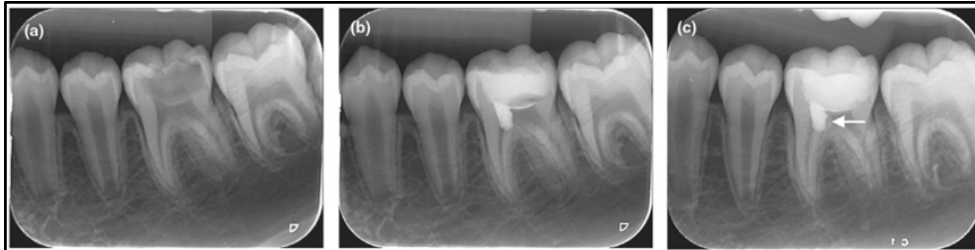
Left mandibular first molar (#36) had caries close to the pulp with a poor occlusal filling, in a 11-year-old girl. (a) A PA preoperative radiograph. (b) Immediate postoperative radiograph after partial pulpotomy. (c) PA radiograph at 6-month follow-up showing the dentine bridge formed on the distal side of iRoot BP Plus (arrow).
